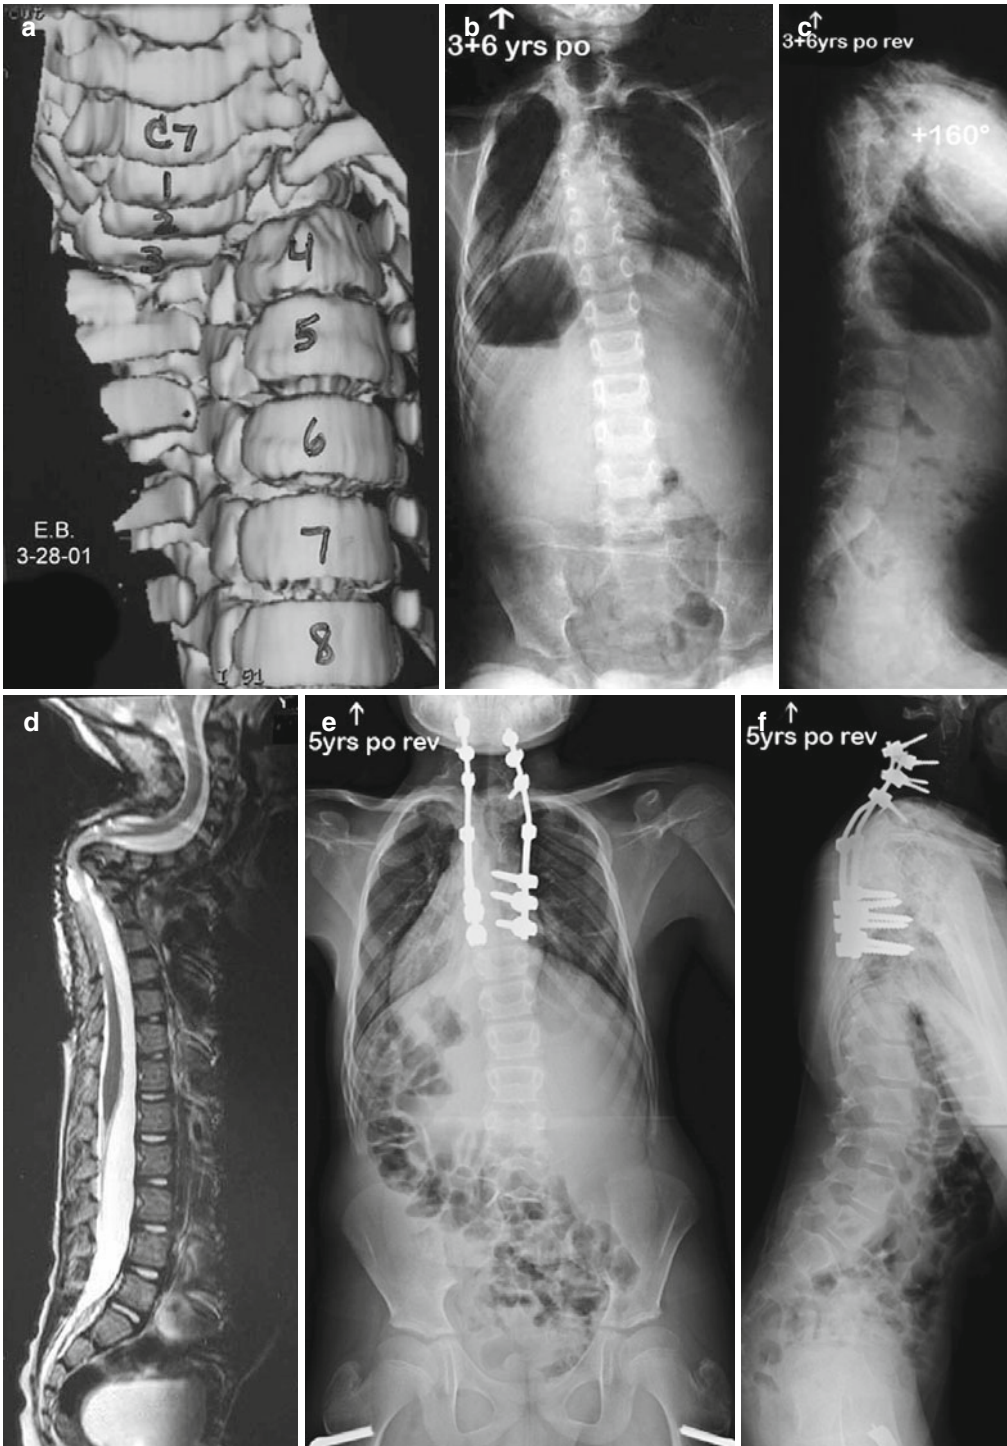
Patient is a 2-year-old boy who presented with a congenital dislocation of T3/T4 as seen on (a) his preoperative coronal 3D CT scan. At three years of age, he underwent in situ fusion with subsequent deformity progression and myelopathy. (b, c) At the age of 5 (3+6-years postoperative), his coronal and sagittal x-rays somewhat hid his severe deformity. (d) However, on his sagittal MRI
